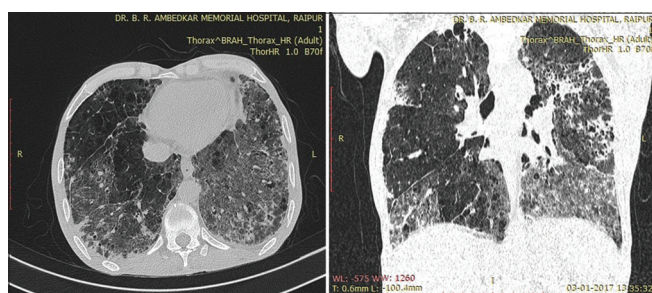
Usual interstitial pneumonia in a 60-year-old male. HRCT axial and coronal reformatted image showing ground-glass opacity with reticular shadowing predominantly involving posterior and lower lung zones. Honeycombing and bronchiectasis can be easily seen
